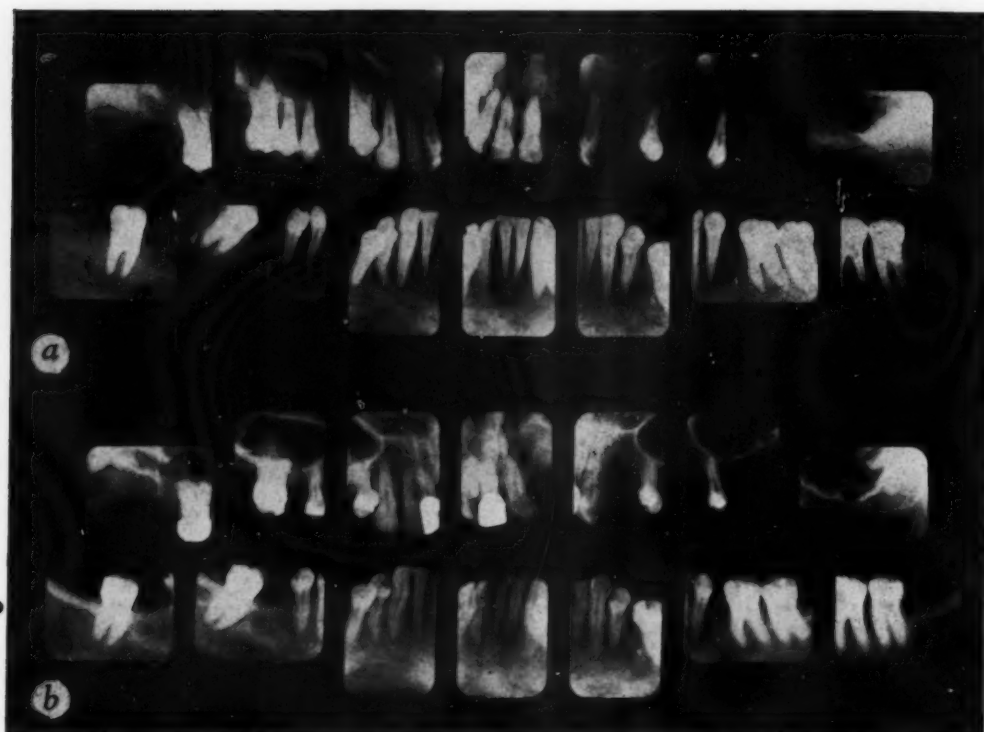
Hyperparathyroidism. *a*. Roentgenogram made prior to treatment, showing marked osteoporosis, absence of lamina dura, spindle-shaped roots, absence of the thin radiopaque lines outlining the maxillary sinuses, and of cortex on the alveolar crest of the mandible. *b*. Roentgenogram made three years after successful treatment, showing reappearance of bone of normal radiographic density, normal lamina dura, normal appearing dental roots, radiopaque lines defining the borders of the maxillary sinuses, and cortex on the alveolar crest of the mandible.
